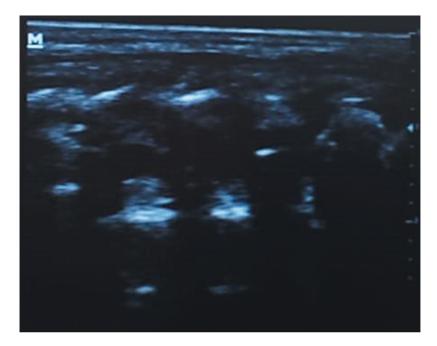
Ultrasound-guided epidural blockade.
